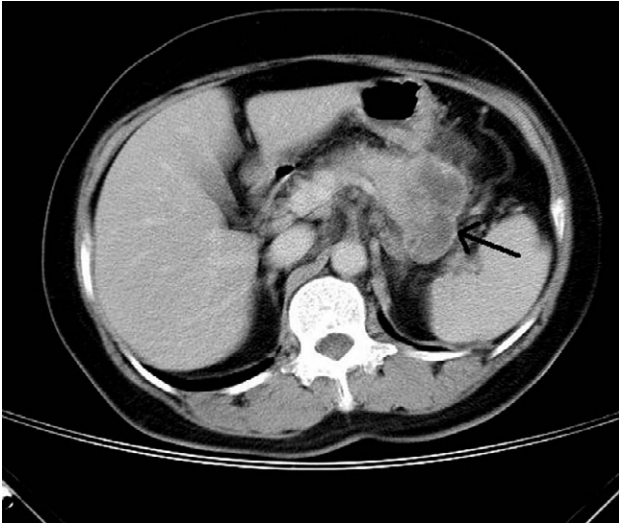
Computed tomography shows pancreatic tail tumor with regional lymphadenopathies (along the aortocaval and paraaortic regions). The tissue plane between the tumor and its adjacent high body of the stomach is obscured, suggesting direct tumor invasion.
